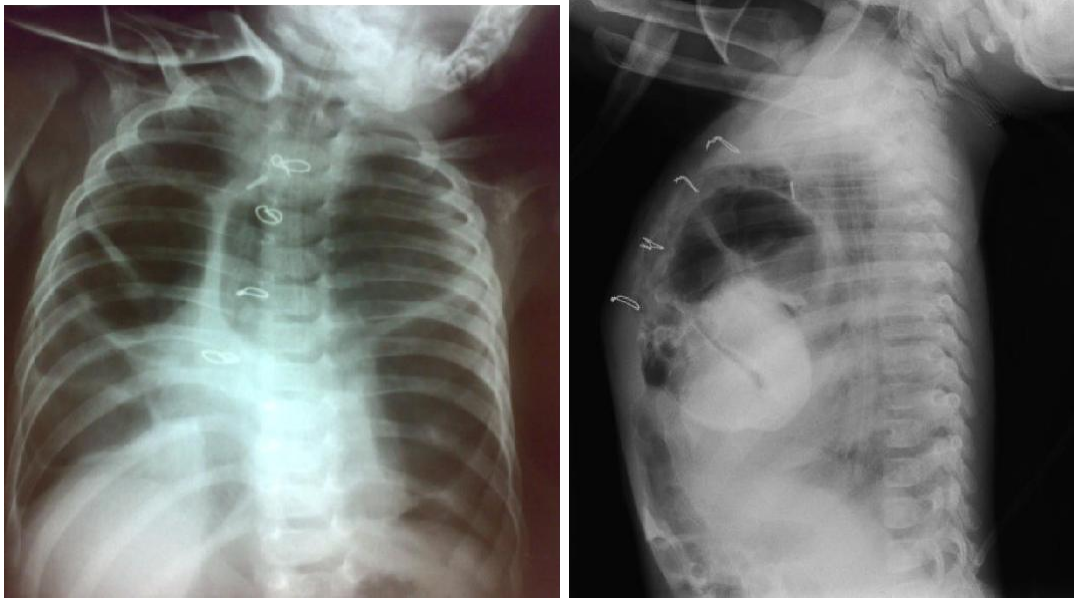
Antero-posterior and lateral chest x-ray showing anterior herniation of bowel loops into the chest. Note the wire from the previous cardiac surgery.
